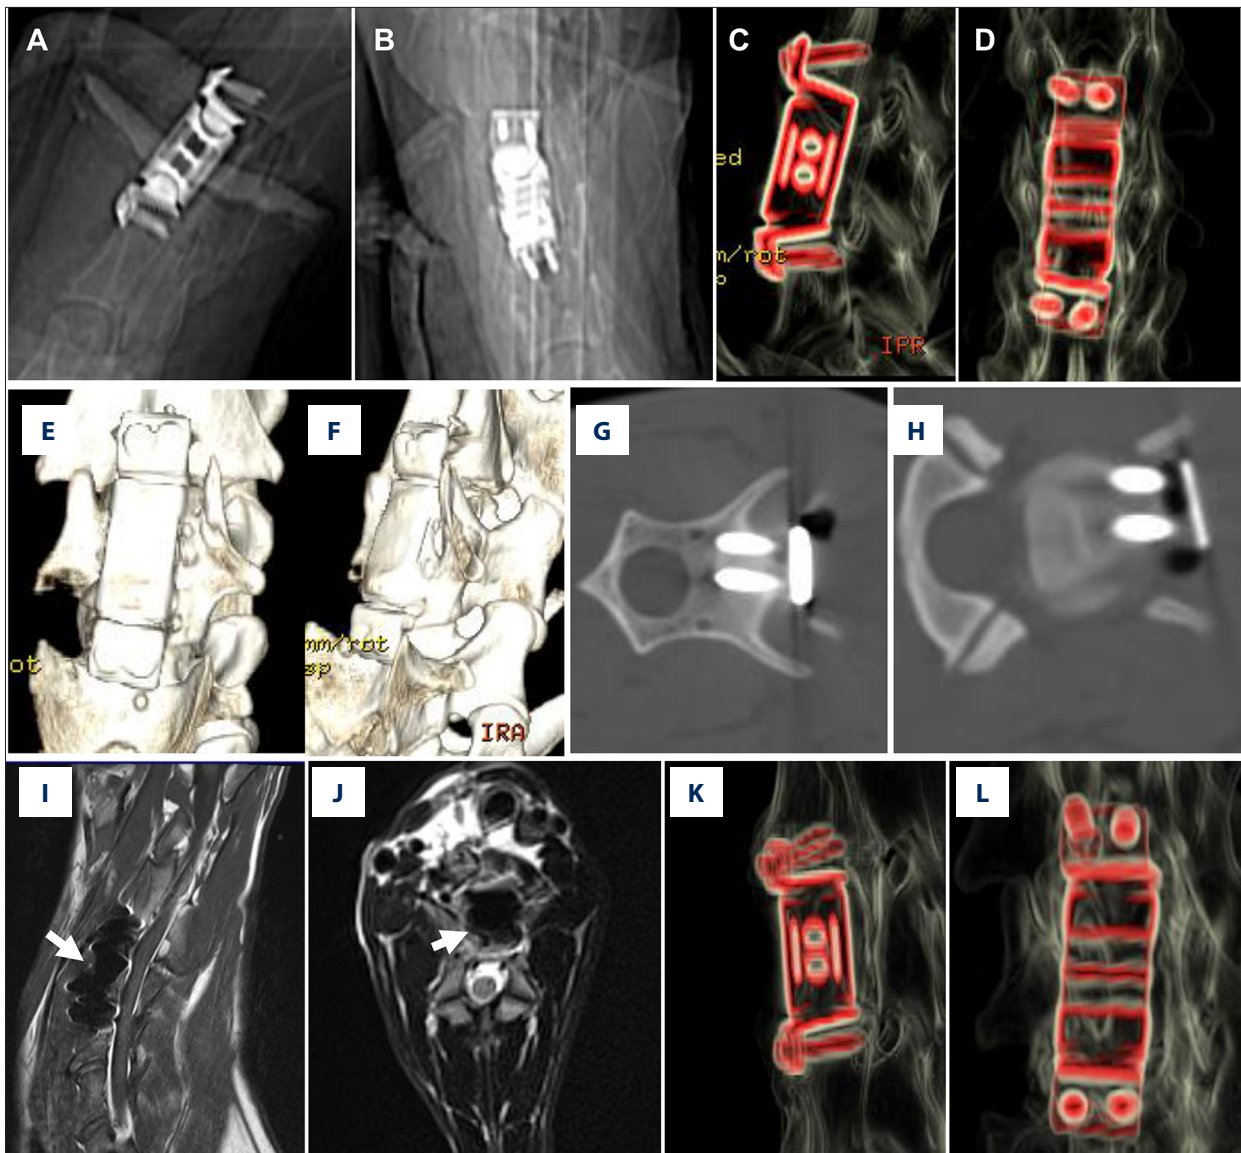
Images of the *in vivo* model. (A) Later view of postoperative X-ray. (B) Anteroposterior view of postoperative X-ray. (C, D) Hardware enhanced reconstruction of postoperative CT. (E, F) Reconstruction of postoperative CT. (G) Screws in C₃ vertebra body. (H) Screws in C₅ vertebra body. (I) Sagittal view of the postoperative T₂ image, the implant (white arrow) did not compress the spinal cord. (J) Axial view of the postoperative T₂ image, no compression to the spinal cord was observed (white arrow indicates the implant). (K, L) Hardware enhanced reconstruction of postoperative CT.
